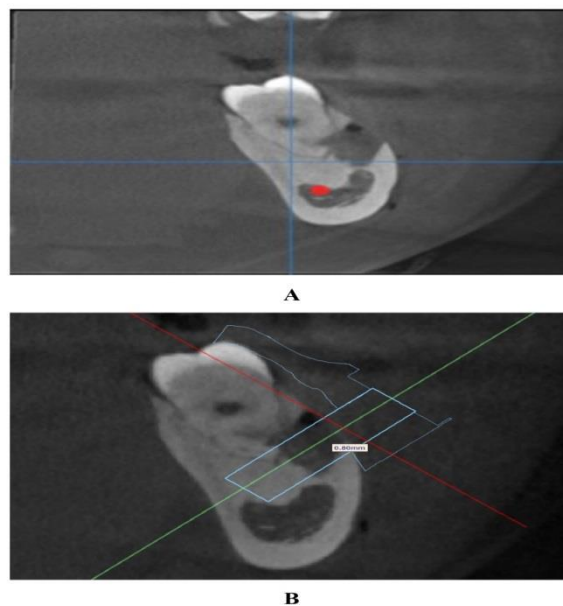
Postoperative (A) CBCT (B) real trephine Bur position
